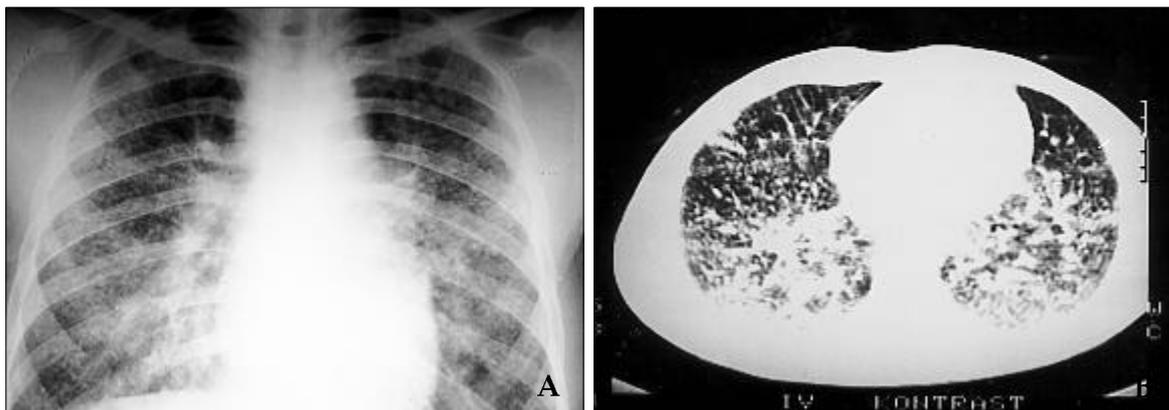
A. Chest X-ray showing micronodular and reticulonodular infiltrates. B. CT scan showing diffuse linear infiltration with patchy soft tissue densities. (Case 1)
